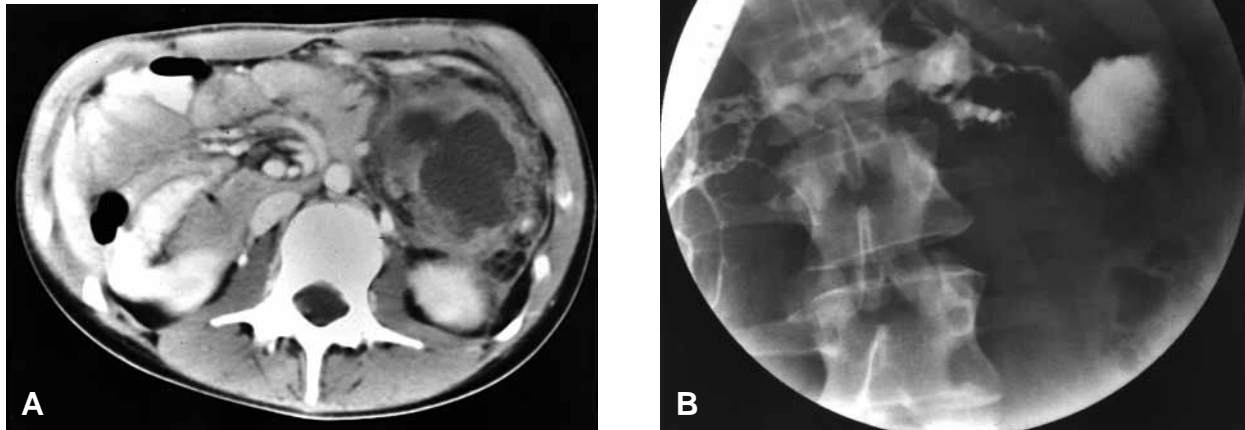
A, Computed tomography showing the original 13-cm cyst adjacent to pancreatic tail at presentation. B, ERCP demonstrates that the cyst communicates with twin dilated pancreatic ducts.
